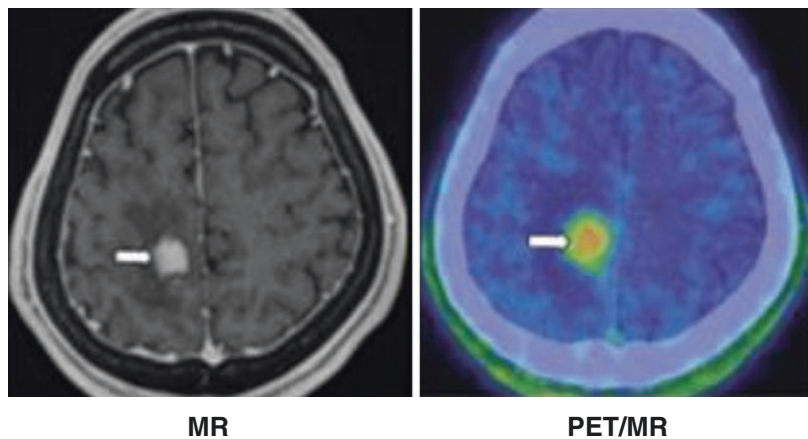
Patient with toxoplasmosis caused by acquired immunodeficiency syndrome. Axial contrast-enhanced T1-weighted image showing clearly enhanced lesion with edema (arrow) in right parietal lobe. PET showing high uptake (arrow) corresponding to lesion, with tumor-to-normal ratio of 4.0 [17]
